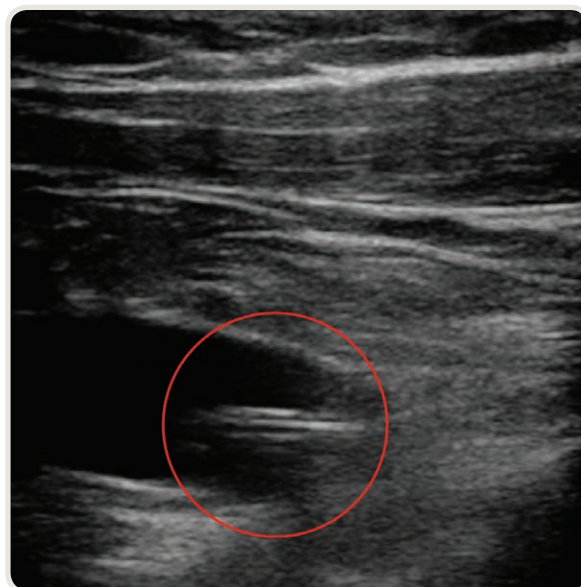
Corresponding ultrasound image of the right subclavian vein in the patient of figure A3.1. The central venous catheter is denoted by the red circle.
